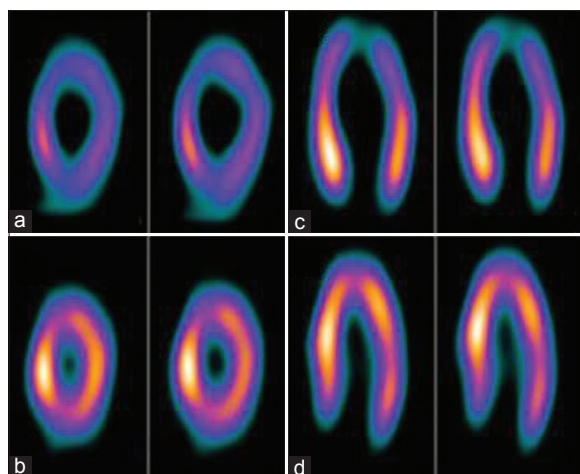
Tc99 MIBI-SPECT images. Early images (a, c) show decreased myocardial perfusion in distal anterior and lateral wall, and apex. (b, d) after complete recovery
